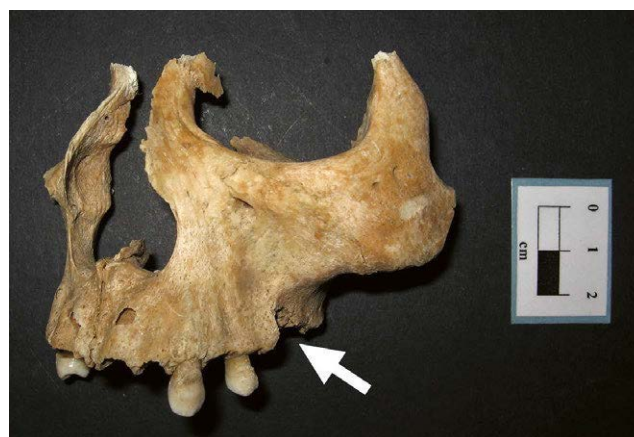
Grave No. 13, pregnant woman's maxilla (periodontal disease, calculus and periapical cystic cavity)
